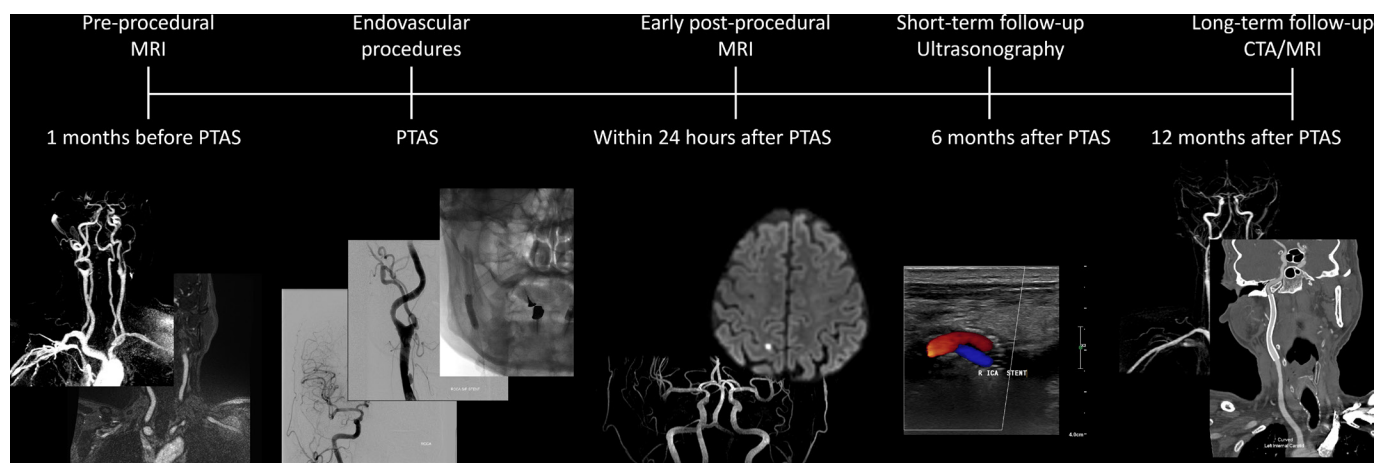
Imaging protocols in this study. Five standardized imaging evaluations were arranged in this study. Preprocedural MRI was performed, and the endovascular procedures were arranged within 1 month after the preprocedural MRI. The endovascular procedures, including percutaneous transluminal angioplasty and stenting (PTAS), were performed with preprocedural digital subtractive angiography (DSA) in the same session. Early postprocedural MRI was conducted within 24 hours after PTAS to evaluate periprocedural safety. Short-term follow-up ultrasonography was performed 6 months after PTAS, and long-term postprocedural CT angiography (CTA) and MRI were performed 12 months after PTAS.
